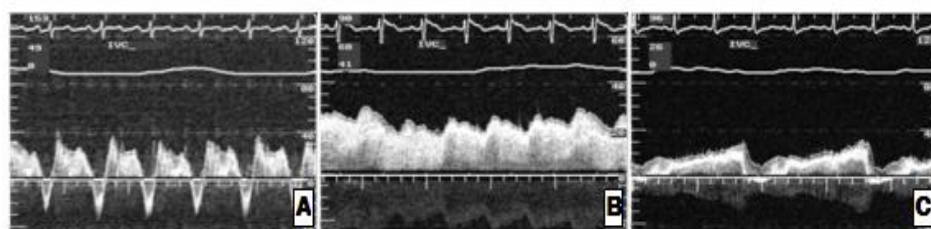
Intravascular Doppler spectrals at IVC in 3 groups (A;APC group, B;LTF group, C;ECF group)
